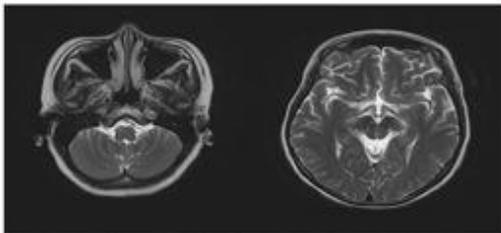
Chronic hypertrophic olivary degeneration. T2 weighted sequence of 3 T MRI demonstrating T2 hyperintense signal in the right olivary nucleus, substantia nigra and red nucleus bilaterally.
